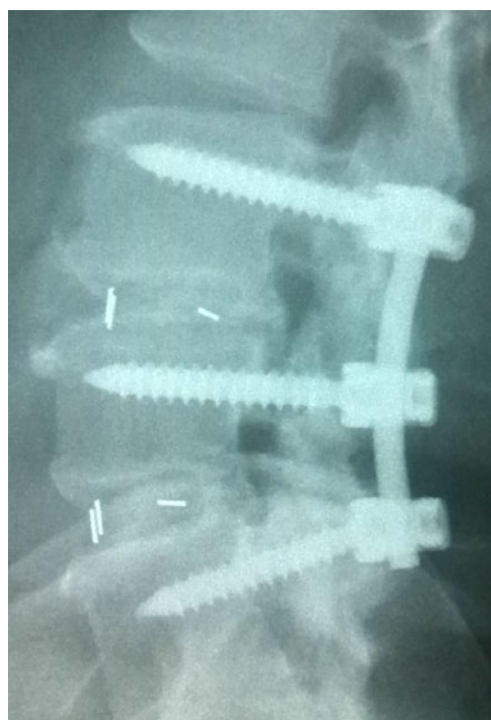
Lateral radiographs taken 2.5-years postoperatively showing solid fusion with trabecular bony bridging across the adjacent vertebrae
